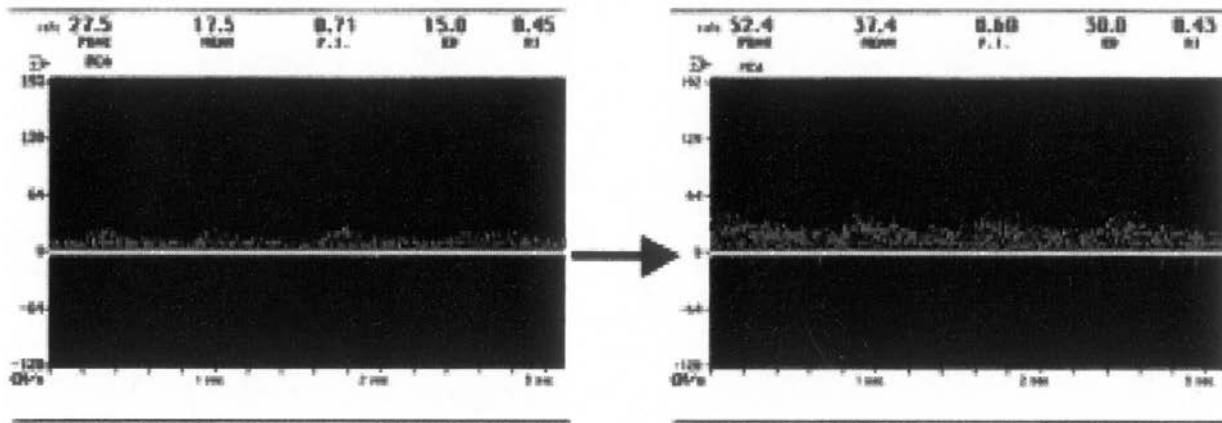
Response to change in head of bed position. Transcranial Doppler images of the right middle cerebral artery. The image on the left shows the wave tracing with the head of bed at 70°. The patient has a moderate left leg paresis. The image on the right shows the response of lowering the head of bed to 0°. The patient had a complete recovery of leg paresis when the head of bed was lowered. (From Alexandrov et al., 2000, with permission.)
